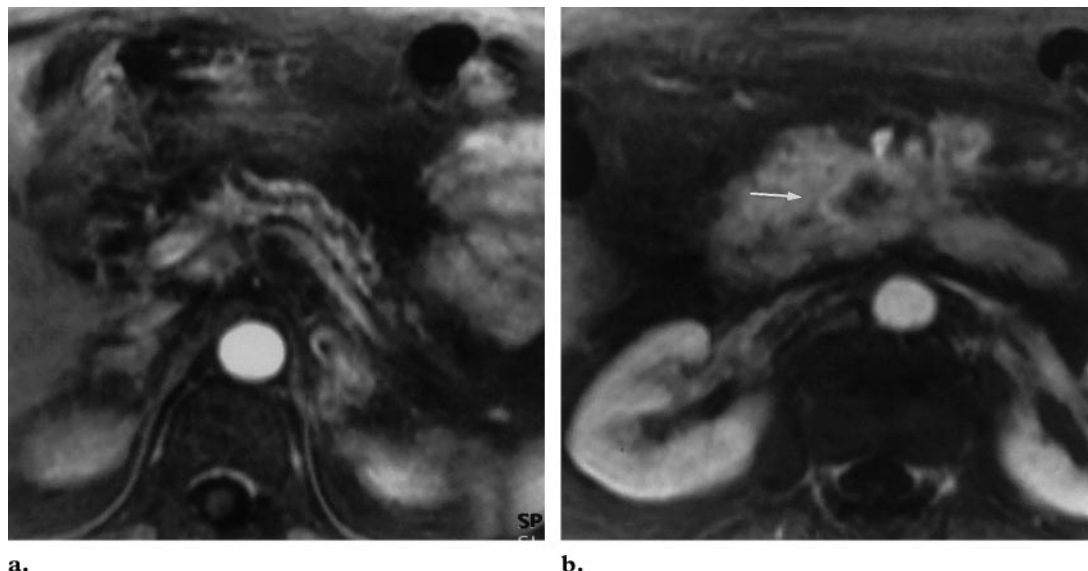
Infiltrating adenocarcinoma of the pancreatic head. (a) Axial gadolinium-enhanced T1-weighted gradient-echo MR image of the pancreas shows a thin biliary tract. (b) Axial gadolinium-enhanced T1-weighted gradient-echo MR image of the pancreas clearly shows the tumor with peripheral enhancement (arrow).
